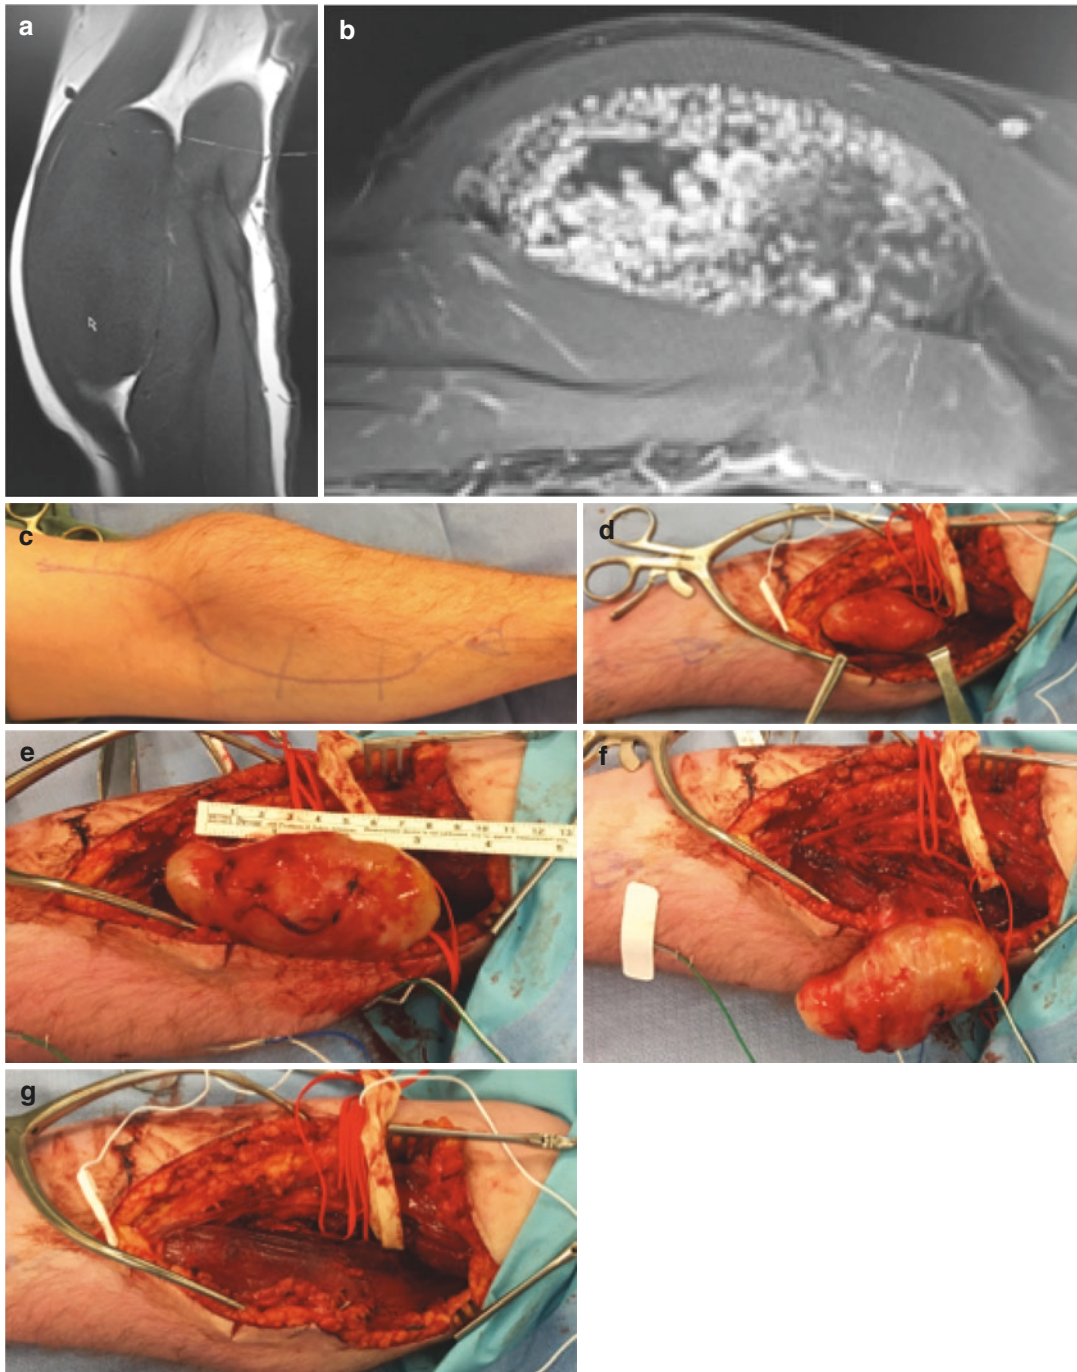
MRI of the ulnar nerve neurofibroma (a). Marking of the skin incision and the approximate location of the tumor (b). After soft tissue dissection, the ulnar nerve and neurofibroma are exposed (c). Photograph of the resected neurofibroma (d). After the microsurgical resection, one can see in the arm the needle electrodes on the hand muscles for EMG recording of the ulnar muscle
